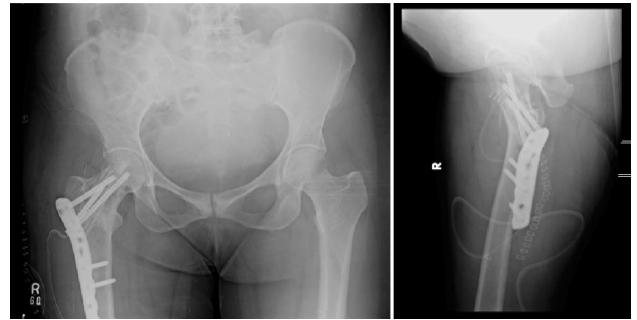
Plain X-rays of case patient after surgical curettage and internal fixation.
